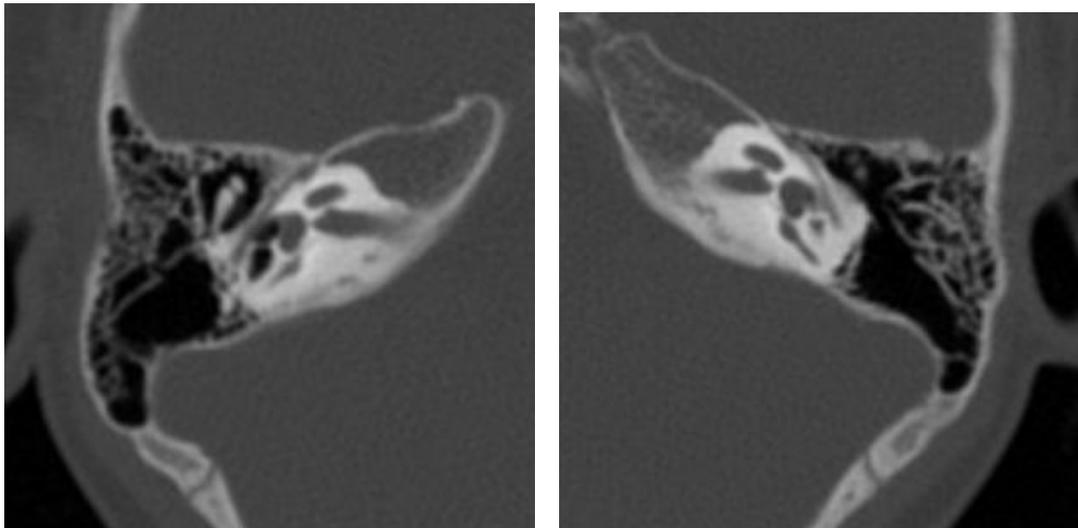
Hypoplastic bony canal for the cochlear nerve in a 7-year-old boy with SNHL. Transverse, thin-section CT scan through the midportion of the modiolus shows a hypoplastic bony canal for the cochlear nerve. The canal width was found to be 0.6mm bilaterally.
